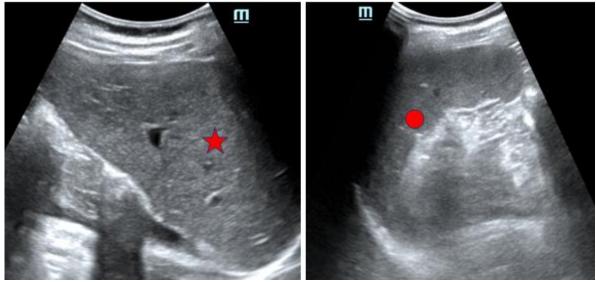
Ultrasonographic images showing liver in left hypochondrium (asterisk) and spleen in right hypochondrium (circle)
